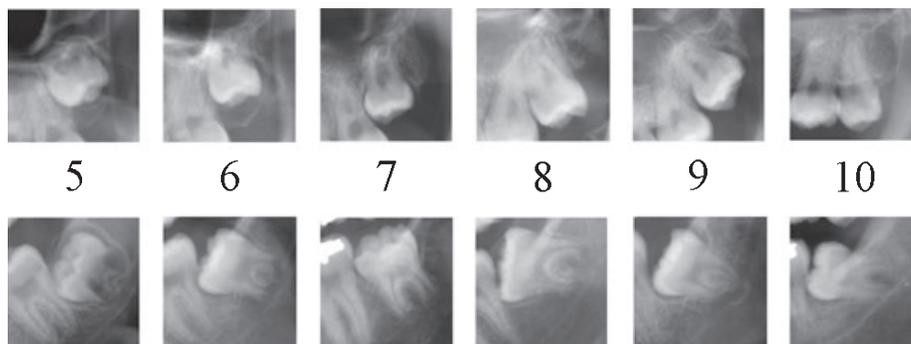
Radiographical images of third molar developmental stages corresponding to scores 5–10 for upper and lower third molars.
